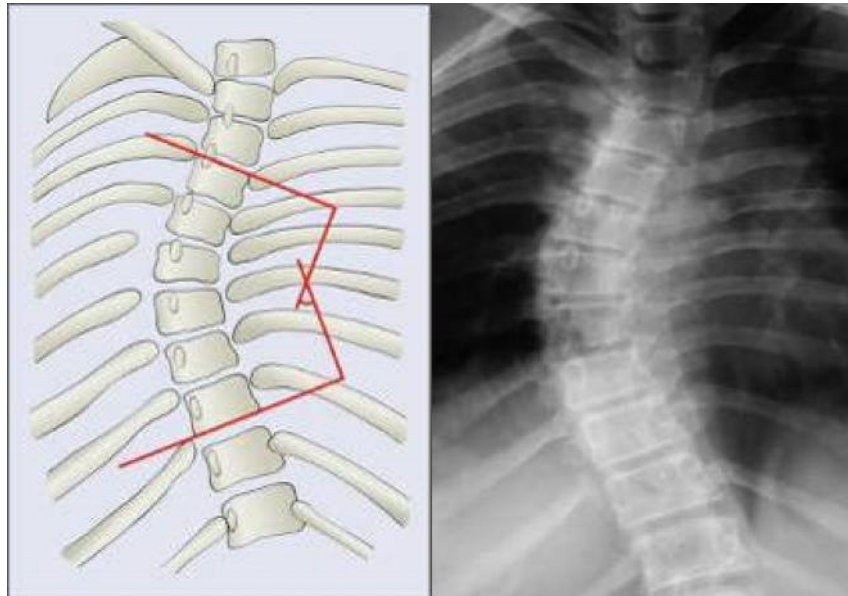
The Cobb angle method of measuring the degree of scoliosis. The physician chooses the most tilted vertebrae above and below the apex of the curve (<http://www.e-radiography.net/radpath/c/cobbs-angle.htm>).
